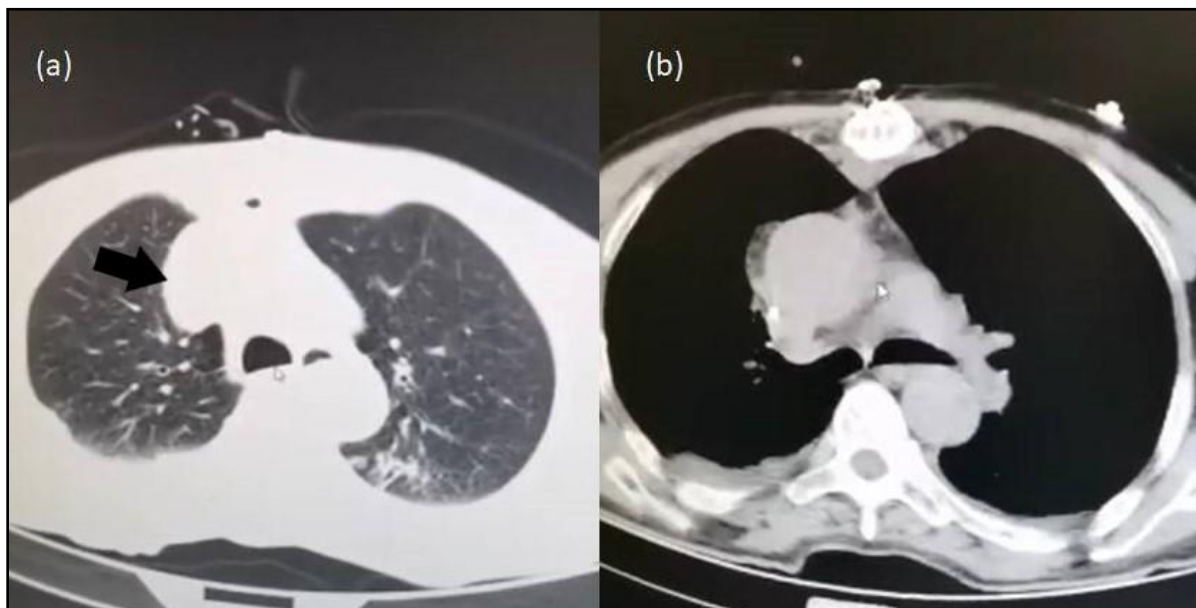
IV Contrast Thorax Computerized Tomography (CT) (Figure 3 A), Postoperative Excised Aneurysm With Normal Aortic Lumen (Figure 3 B)
